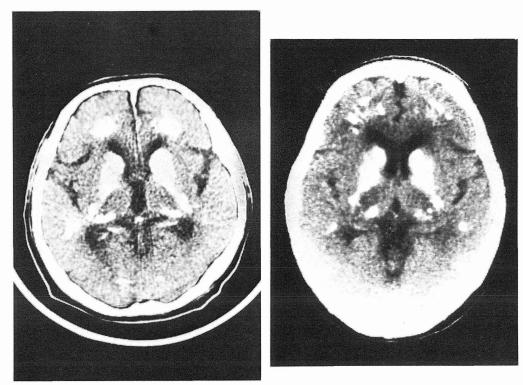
CT scan. Case 1 (left) and Case 2 (right). Dense, extensive calcification of the basal ganglia, the dentate nuclei, and the cerebral cortex.
